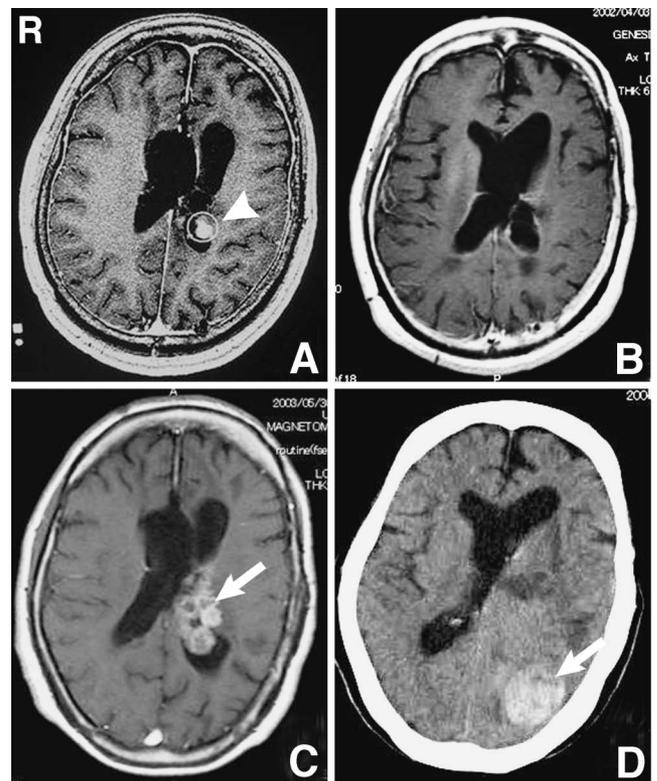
Case 2. (A) Axial T₁-weighted magnetic resonance (MR) image with gadolinium enhancement at second gamma knife radiosurgery (GKS) demonstrating the 75% isodose curve surrounding the margin of the recurrent tumor in the left lateral ventricle, mainly in the inferior horn (arrowhead). (B) Follow-up MR image showing significant reduction in the tumor volume 6 months after second GKS. (C) Repeat MR image at 19 months after second GKS suggesting increased tumor volume (arrow) which was treated subtotally by third craniotomy. (D) Computed tomography scan 17 months after third craniotomy showing rapid progression of the residual tumor and intracerebral hemorrhage in the left occipital lobe (arrow).
